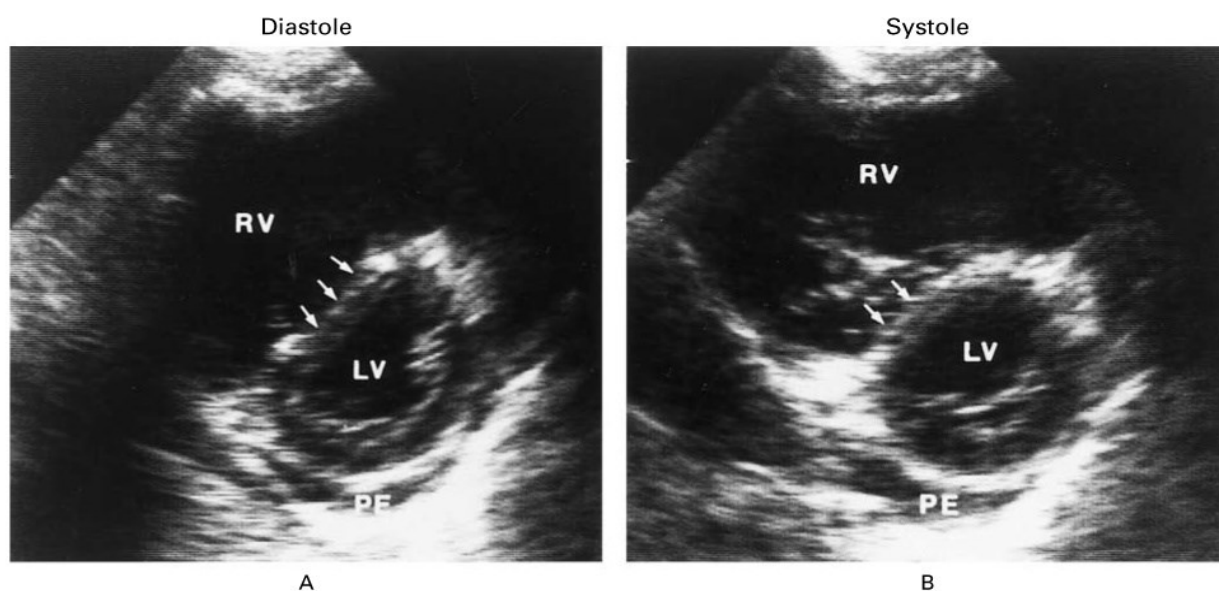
Typical Findings of Transthoracic Echocardiography in Patients with Massive PE (71).*
